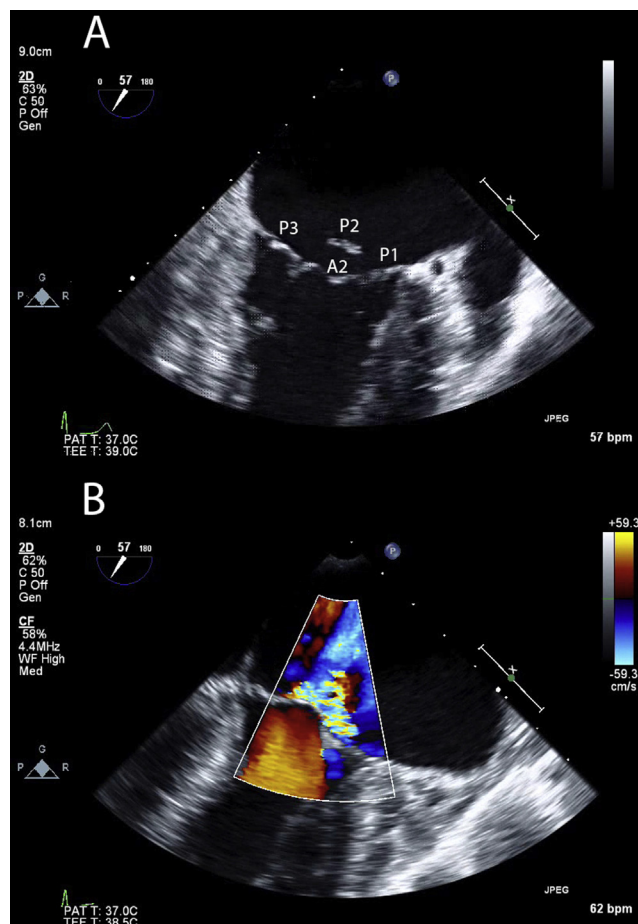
The cobra sign due to P2 flail. (A) With 2D imaging, the prolapsing P2 segment can be seen above the A2 segment (late systole, mid-esophageal commissural view). (B) With color flow Doppler, a broad jet of MR is seen above A2 (late systole, mid-esophageal commissural view).
